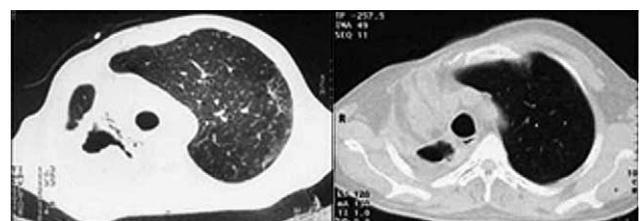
Case 1, pre-operative CT: left, post-operative CT: right.
